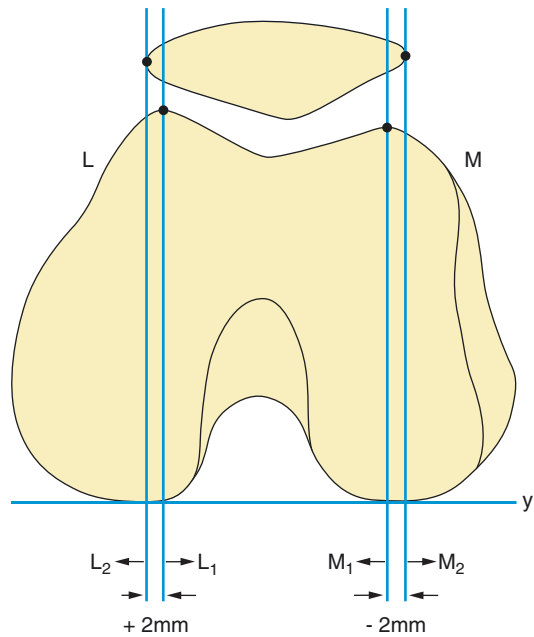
Measurement of lateral patellar displacement on CT or MR imaging measured relative to the summits of both the medial and lateral femoral condyles. All lines are drawn perpendicular to the posterior condylar line (Y). M_1 and L_1 are reference lines through the summits of the medial and lateral femoral condyles, respectively, whilst M_2 and L_2 are drawn through the medial and lateral patellar margins, respectively. The distances $M_2 - M_1$ and $L_2 - L_1$ are calculated such that a positive value is given where the patellar line is lateral to its corresponding trochlear reference line. The lateral patellar displacement is taken as the mean of the two measurements (0 mm in this example)
